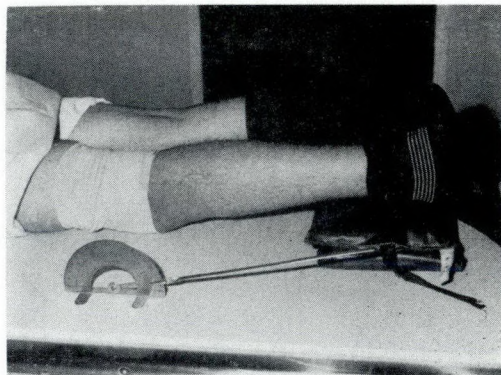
On a PA projection with the x-ray tube vertical, the foot is elevated on a sand-bag, 6 to 12° as measured by the protractor to compensate for the tilt of the tibial plateau.
